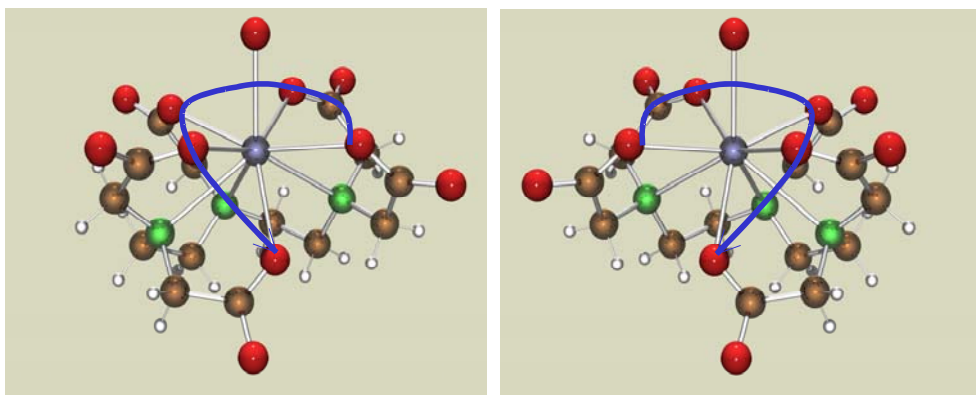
X-ray structure of $\text{Eu}(\text{DTPA})^{2-}$ (ball and stick representation) showing the two different arrangements of the acetate arms in the enantiomers
